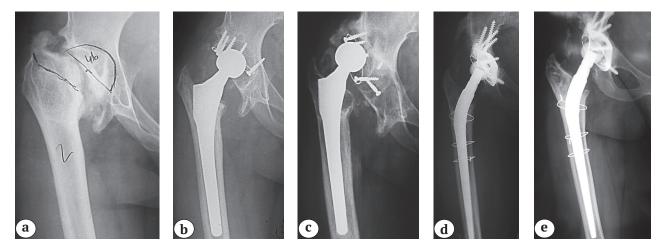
X-rays of female patient 16 y.o.:
